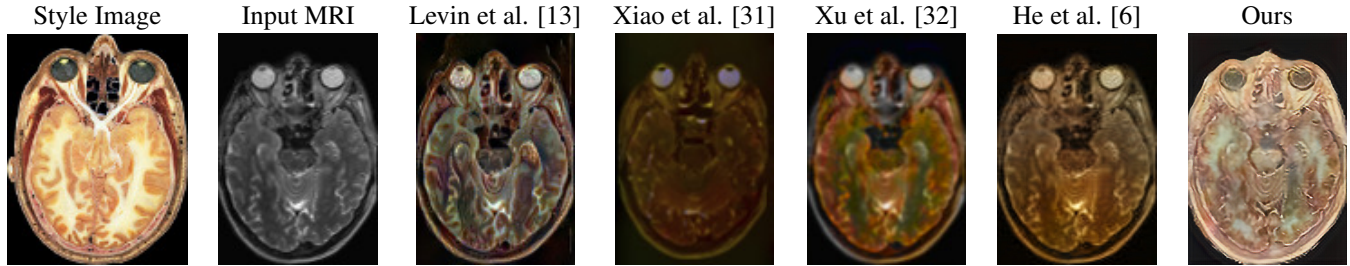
Comparison with exemplar colorization methods. For a particular style image, our method results in a much better visual perception. This demonstrates that exemplar colorization that cannot be performed on the MRI directly due to the nature of image modality.
